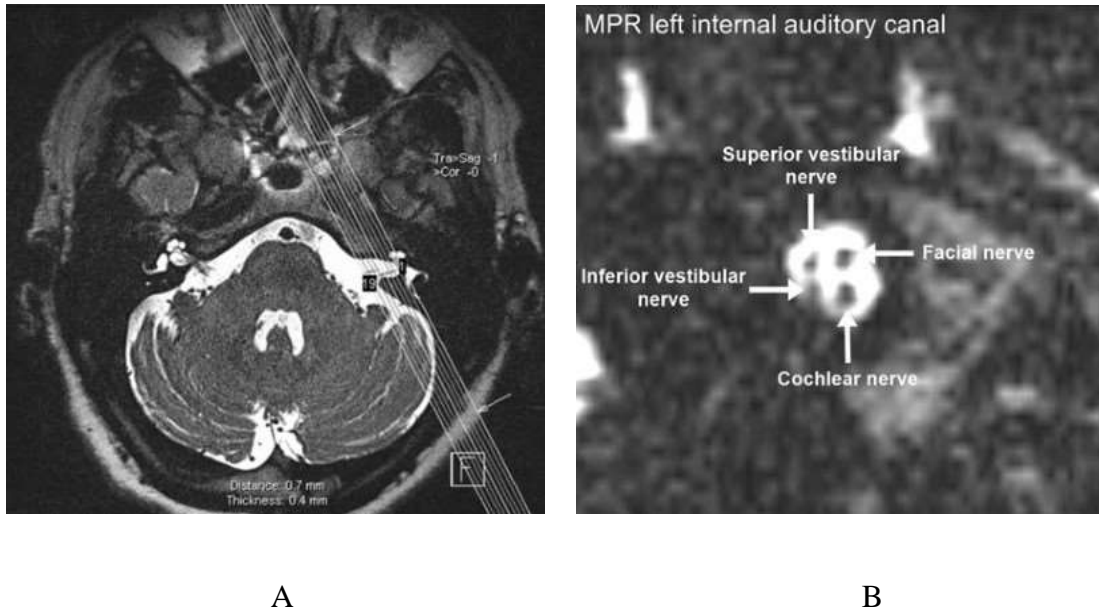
Axial high-resolution T2 weighted MRI at the level of IAC. The left (A) show the orientation of the parasagittal multiplanar reconstruction (MPR) of the IAC and right (B) show the cochlear, facial, and superior and inferior vestibular nerves (Naguib et al., 2017).
